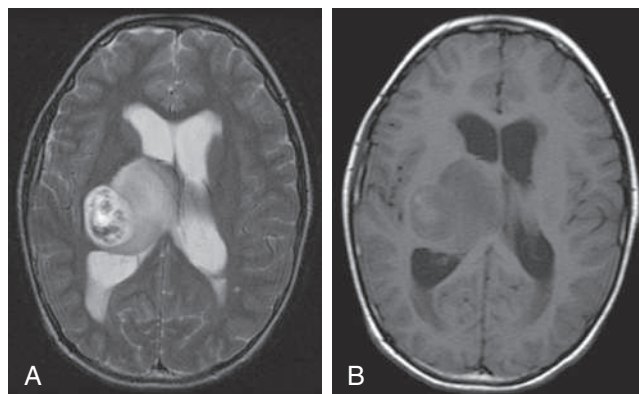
A, Nonenhanced axial T2-weighted MR image of grade III astrocytoma of the right thalamus demonstrating diffuse hyperintensity and area of necrotic cyst formation. B, Gadolinium-enhanced sagittal T1-weighted MR image showing slight enhancement and hypodensity of grade III astrocytoma of the thalamus. This 14-yr-old child presented with left arm and leg numbness and weakness and right-sided headaches.
